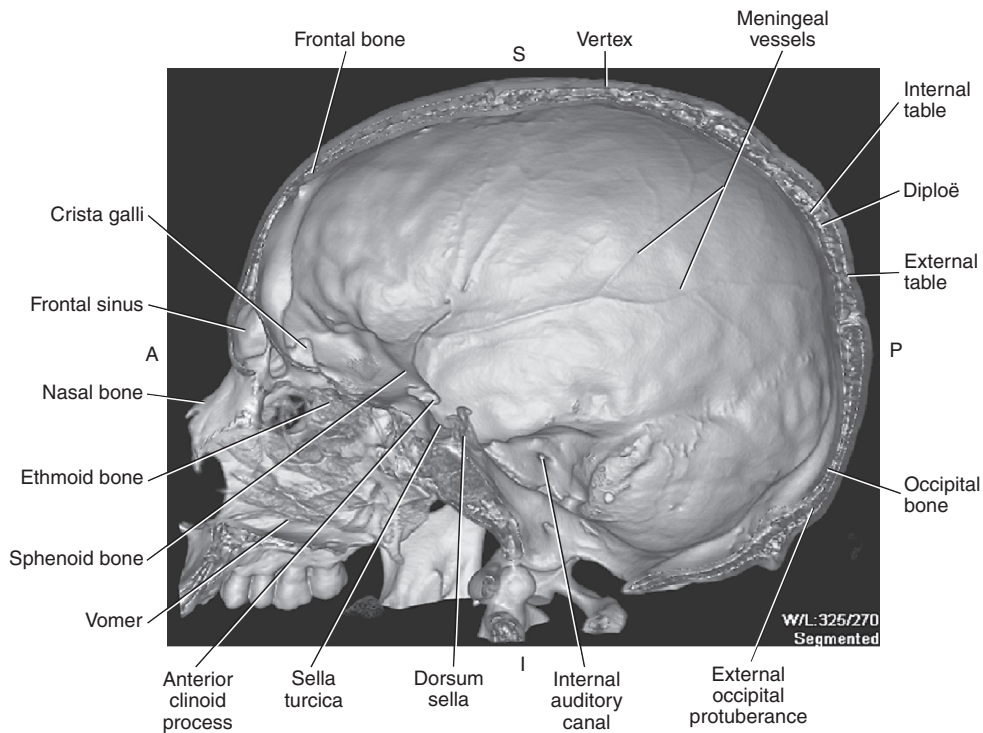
3D CT of inner skull, lateral view.
